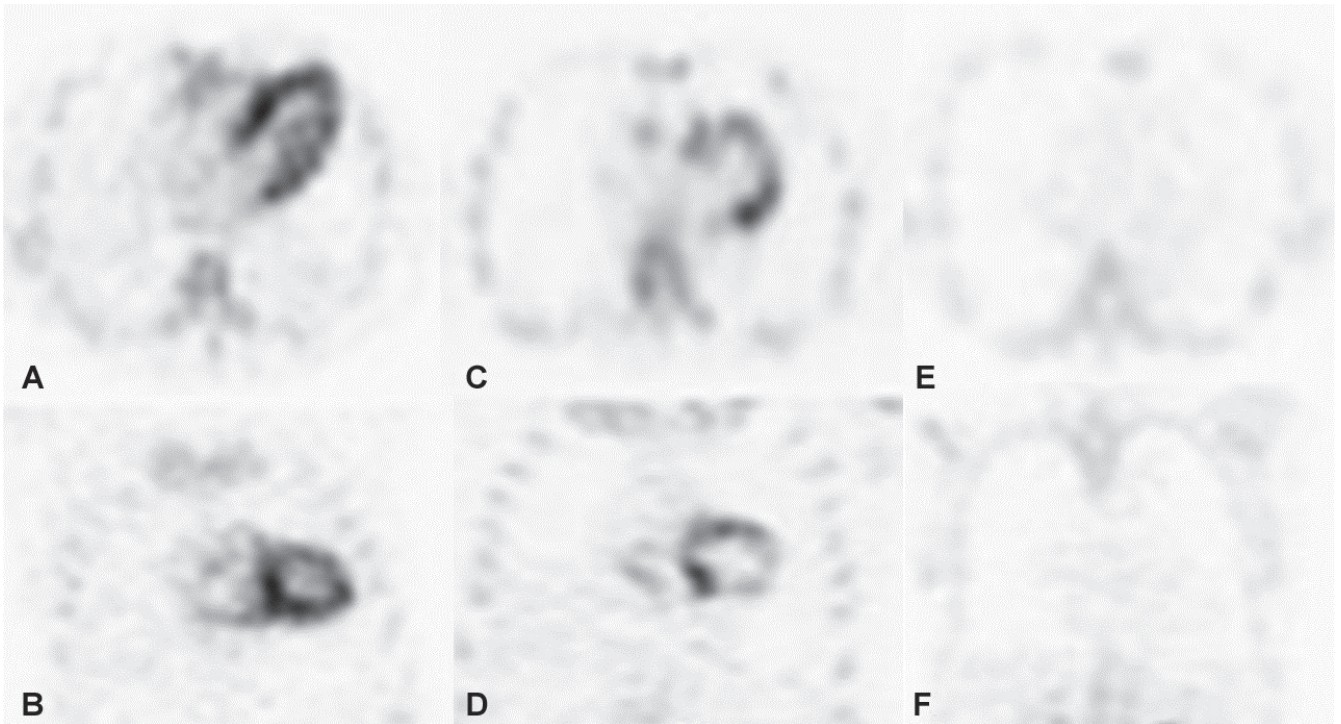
3,3-diphosphono-1,2 propanodicarboxylic acid (DPD)-single-photon emission computed tomography (SPECT)
